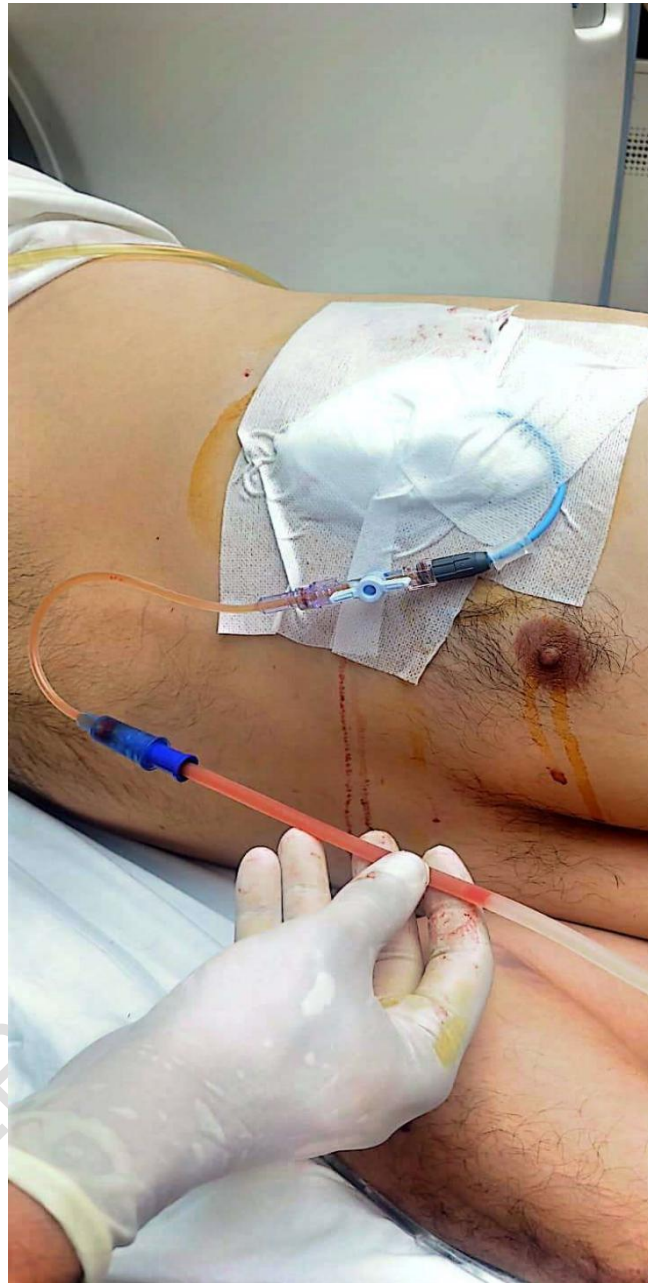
CT-guided aspiration and drainage of the hepatic abscess
